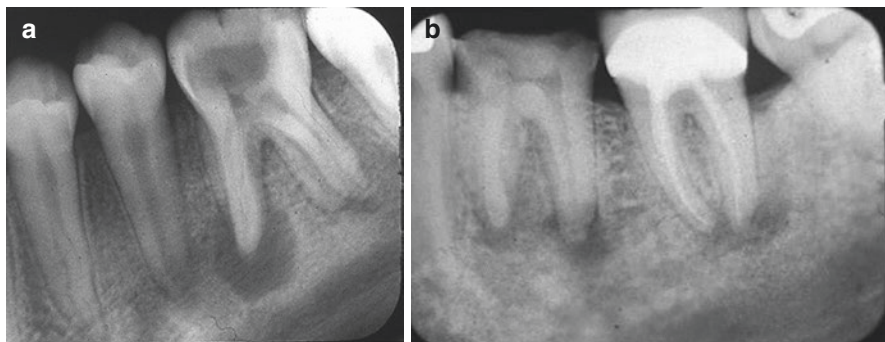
(a) PA radiograph showing caries, widened PDL space and a pericarpial radiolucency involving the mesial root of #19. (b) Endodontically treated #18 and grossly decayed #19 showing apical pathology/infection with sclerotic changes involving the surrounding trabecular bone
